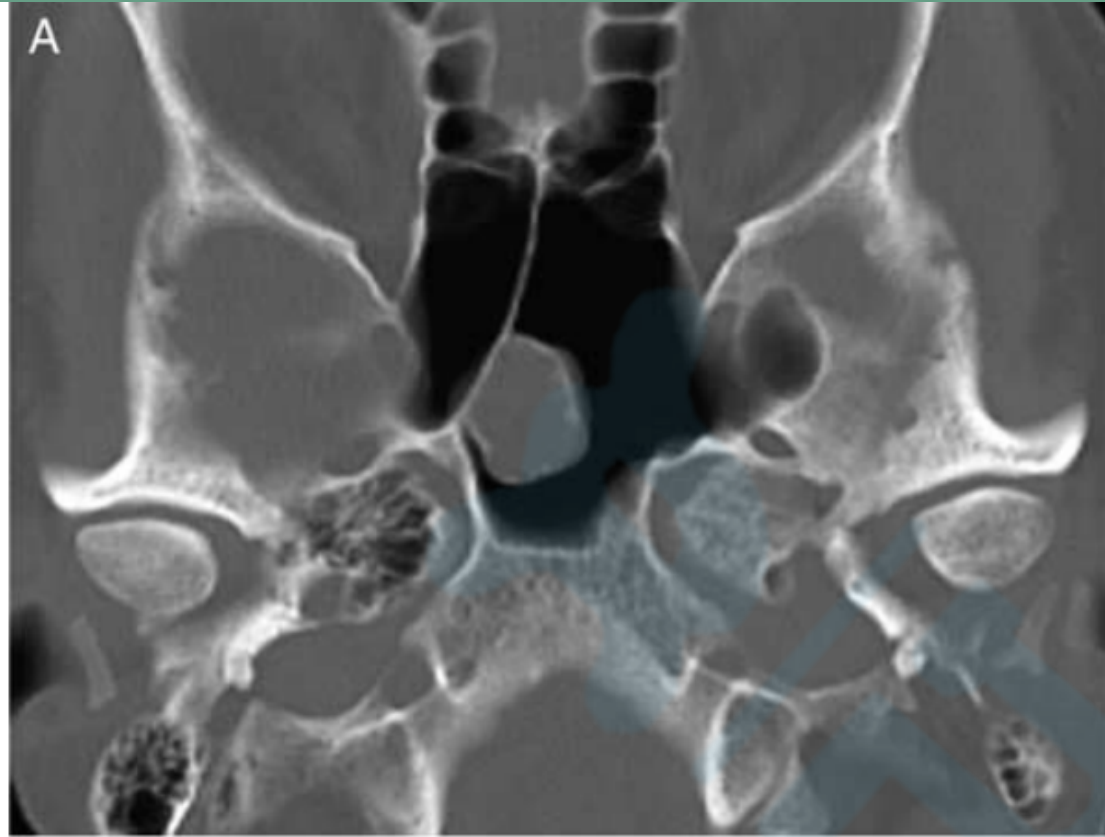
Radiographic examples of craniofacial CMF. Many tumors occurred superficially within existing sinus cavities (A) with some showing focal bony erosion and extension into adjacent sinuses (B). C, Occasional tumors demonstrated frank destruction of involved bones. D, T2-weighted magnetic resonance imaging image of a lesion occurring within the mastoid region with intra-cranial extension.
